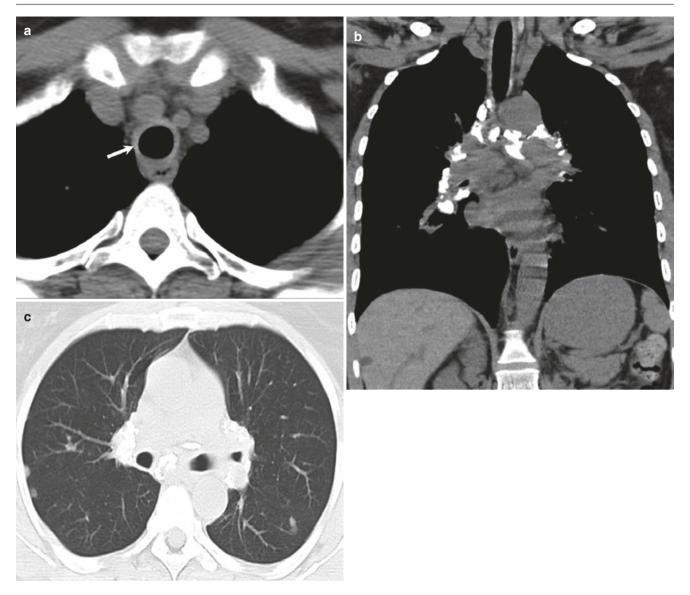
A 58-year-old man with sarcoidosis. (a) Axial CT image shows circumferential thickening of the trachea. (b) Coronal CT image shows bulky hilar and mediastinal lymphadenopathy with calcification. (c) Axial CT image shows typical perilymphatic nodules of sarcoidosis
